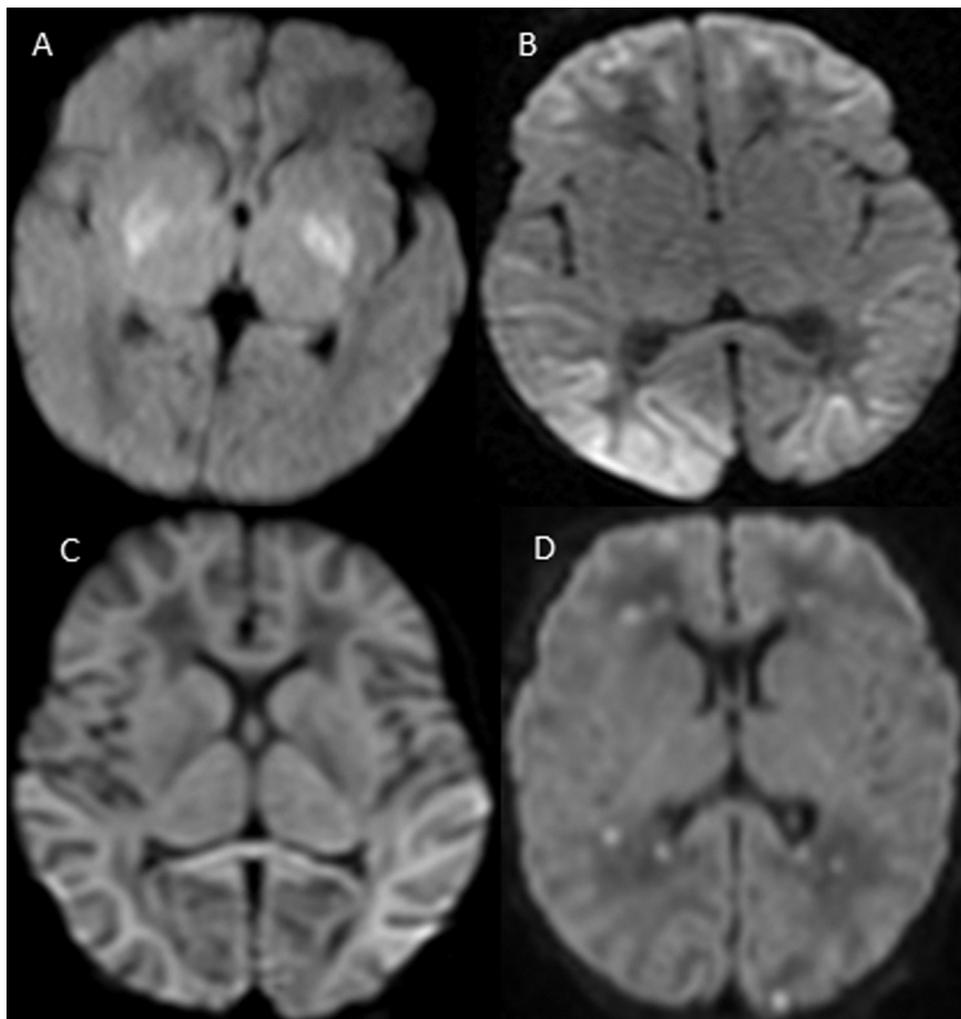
Hypoxic-ischemic encephalopathy patterns of brain injury on axial diffusion-weighted magnetic resonance imaging sequence where injured tissue is defined by restricted diffusion (hyperintense). (A) Acute profound asphyxia with basal ganglia involvement, (B) partial prolonged asphyxia with bilateral subcortical white matter involvement, (C) total asphyxia with basal ganglia and white matter involvement, and (D) multifocal, multiple small restricted diffusion areas.
